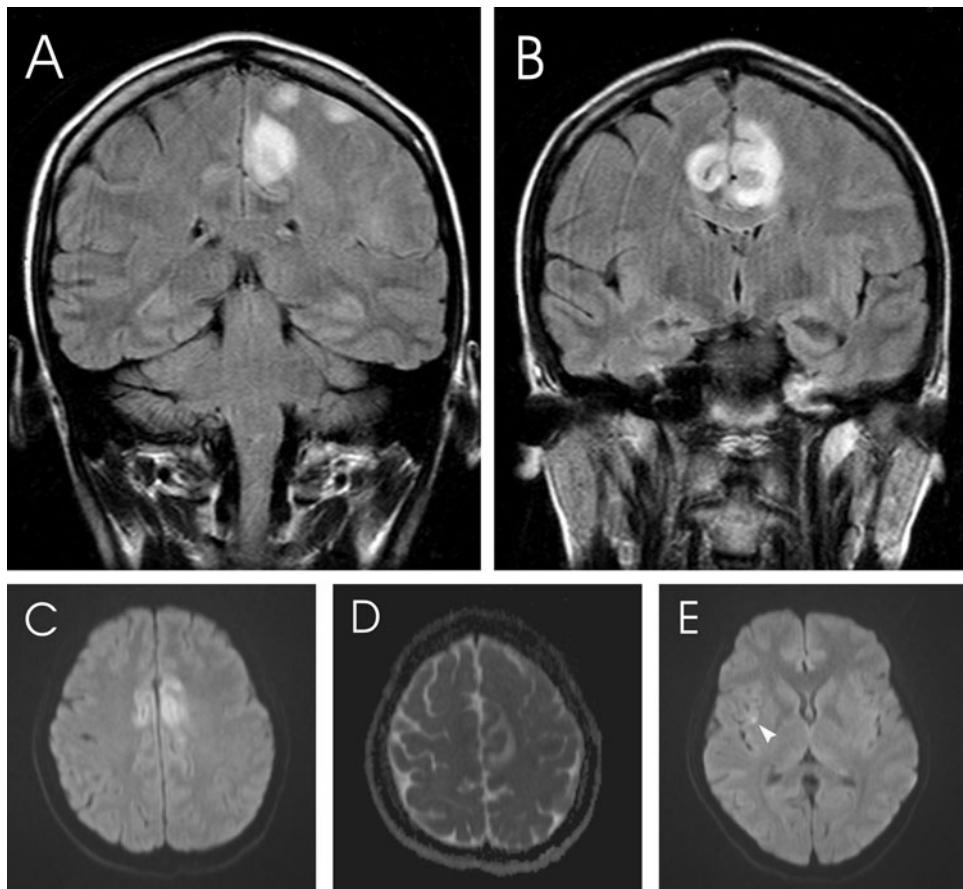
Initial MRI, coronal fluid-attenuated inversion recovery (FLAIR) (A) reveals patchy foci of T2 hyperintensity in the left cingulate gyrus, and over the left frontal lobe in the superior frontal gyrus with involvement of gray and white matter. Coronal FLAIR more anteriorly (B) shows bilateral cingulate gyrus involvement and extension upwards into the left frontal lobe medially and there is mild mass effect. Diffusion trace image (C) shows restricted diffusion bilaterally in the cingulate gyri. Apparent diffusion coefficient (ADC) map (D) shows reduced ADC in the left frontal cortex, which indicates severe cellular swelling, cytotoxic edema, or hypercellularity. Diffusion trace image (E) reveals a very small focus of diffusion abnormality in the right insula (*arrowhead*), which is difficult to appreciate on the ADC map and was recognized only retrospectively.
